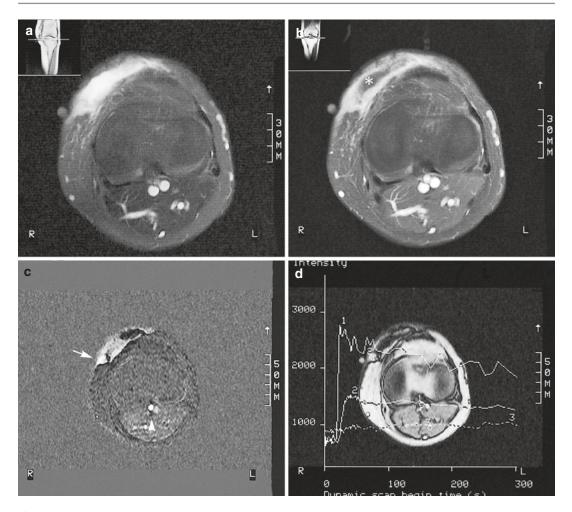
(a–d) Detection of residual tumor with dynamic MRI. A 58-year-old woman referred for an MRI examination after marginal resection of what was originally thought to be a lipoma but proved to be a myxofibrosarcoma. (a) Axial fat-saturated, turbo spin-echo T2-weighted image (1,901 ms/100 ms) at the level of the scar, which is marked with a vitamin A pearl. There is a nonspecific area of high signal intensity within the subcutaneous tissue; differentiation of residual tumor tissue and granulation tissue is not possible. (b) Static T1-weighted, contrast-enhanced image with fat-selective presaturation displays nonspecific enhancement of the scar region: differentiation of residual tumor tissue and granulation tissue is not possible. The nonenhancing
